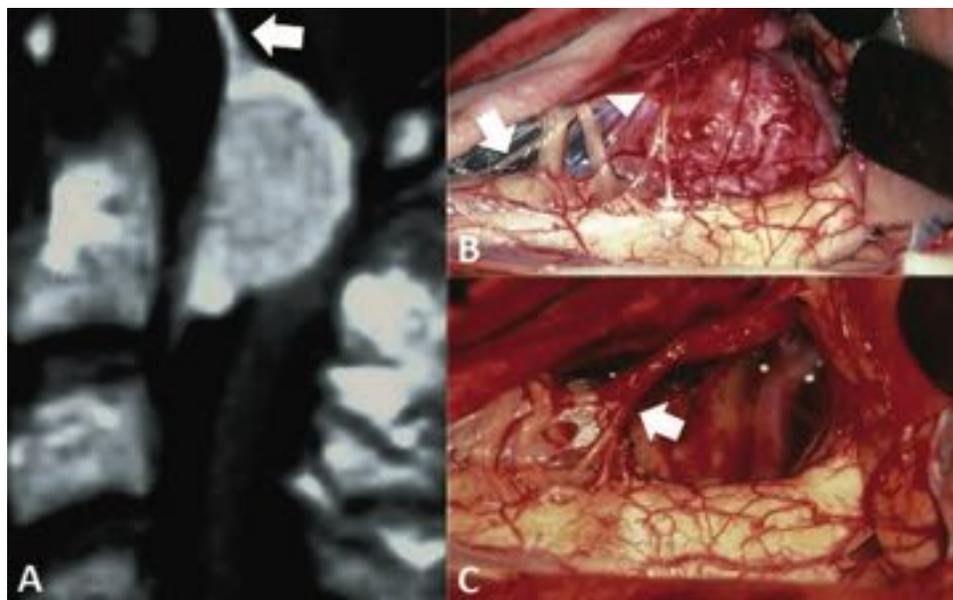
(A) T1 sagittal magnetic resonance imaging with contrast demonstrates a ventral spinal meningioma at the level of C1/C2 with a dural tail extending rostrally to the foramen magnum (arrow). (B) At initial exposure, the dentate ligament (arrowhead) and spinal accessory nerve (arrow) are seen in contact with the tumor. (C) The postexcision tumor bed is shown with the spinal accessory nerve clearly preserved (arrow).
